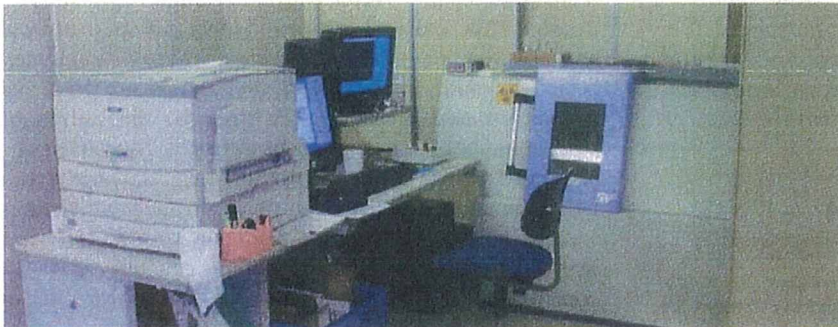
Microfocus X-ray television system (SMX-100CT, Shimadzu Corporation).
